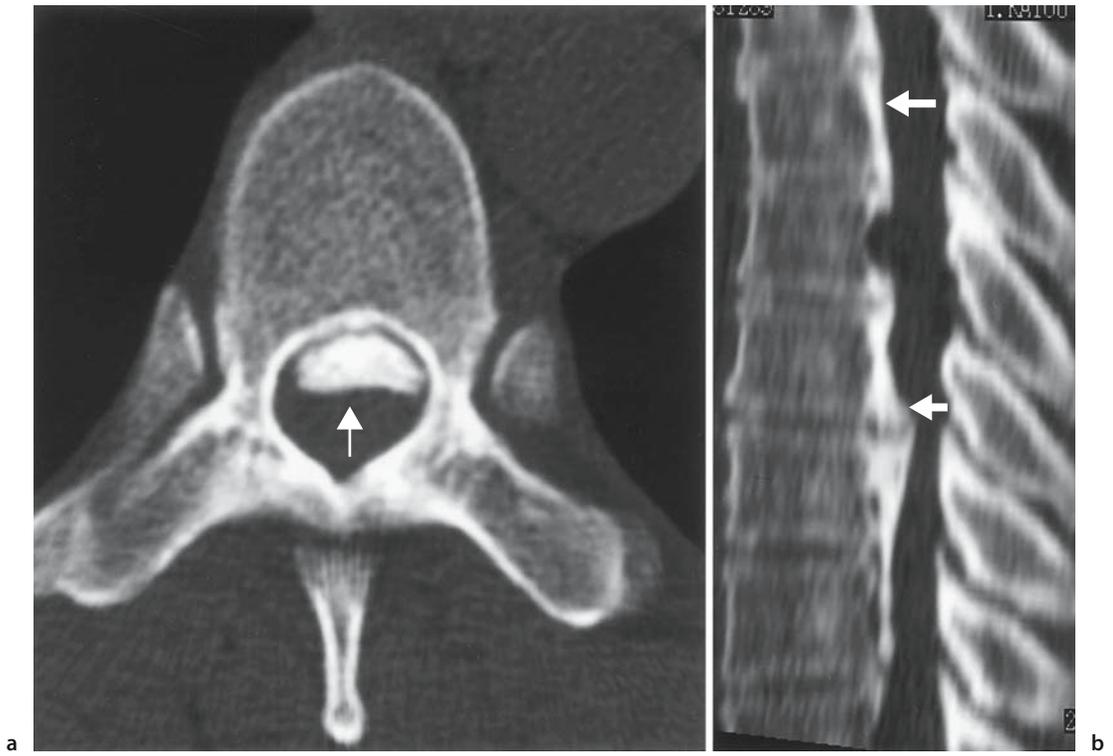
CT of thoracic OPLL: axial image (a) and reconstructed sagittal image (b). Arrows, OPLL
